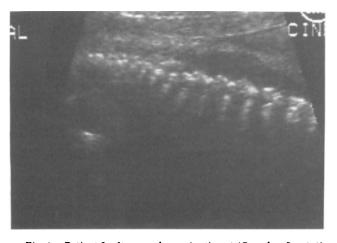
Patient 2, ultrasound examination at 17 weeks of gestation demonstrates a scalloped or wrinkled appearance of vertebral disorganization.
